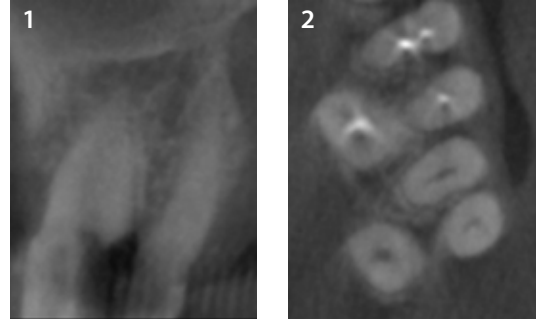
CBCT of tooth 27
